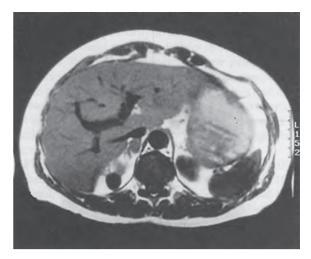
MRI of the abdomen in a patient with Conn syndrome due to right adrenal cortical adenoma.
